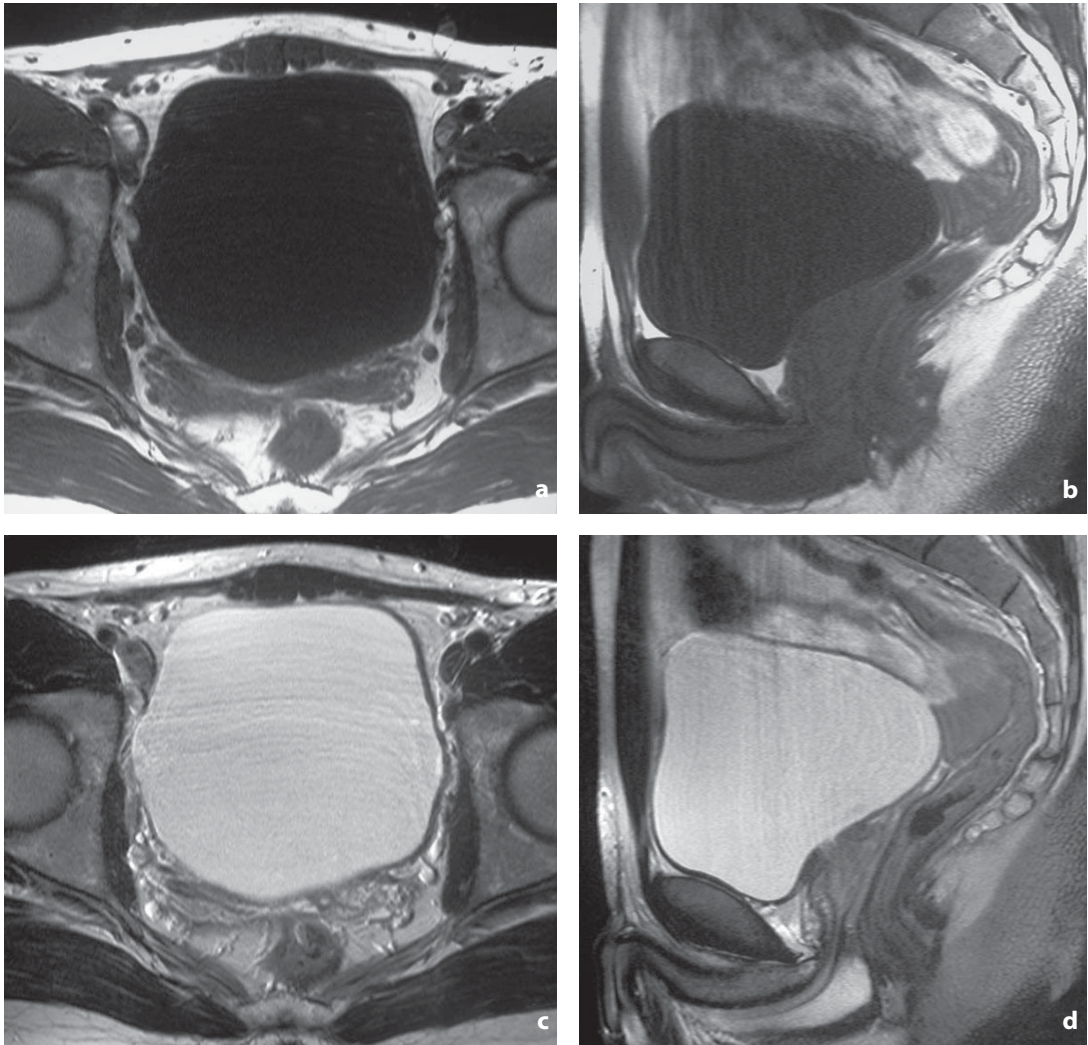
Magnetic resonance. Urinary bladder. Axial (a) and sagittal (b) T1-weighted images. The signal of the wall is of middle intensity, while the urine is hypointense. Axial (c) and coronal (d) T2-weighted images. The urine has a hyperintense signal
